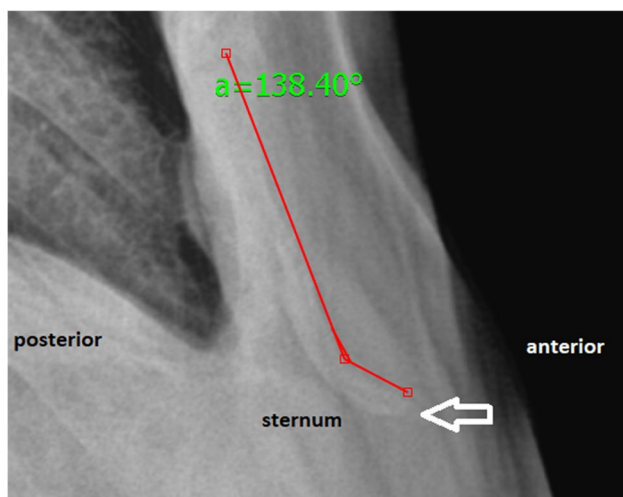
Sternal angulation on lateral chest X-ray
